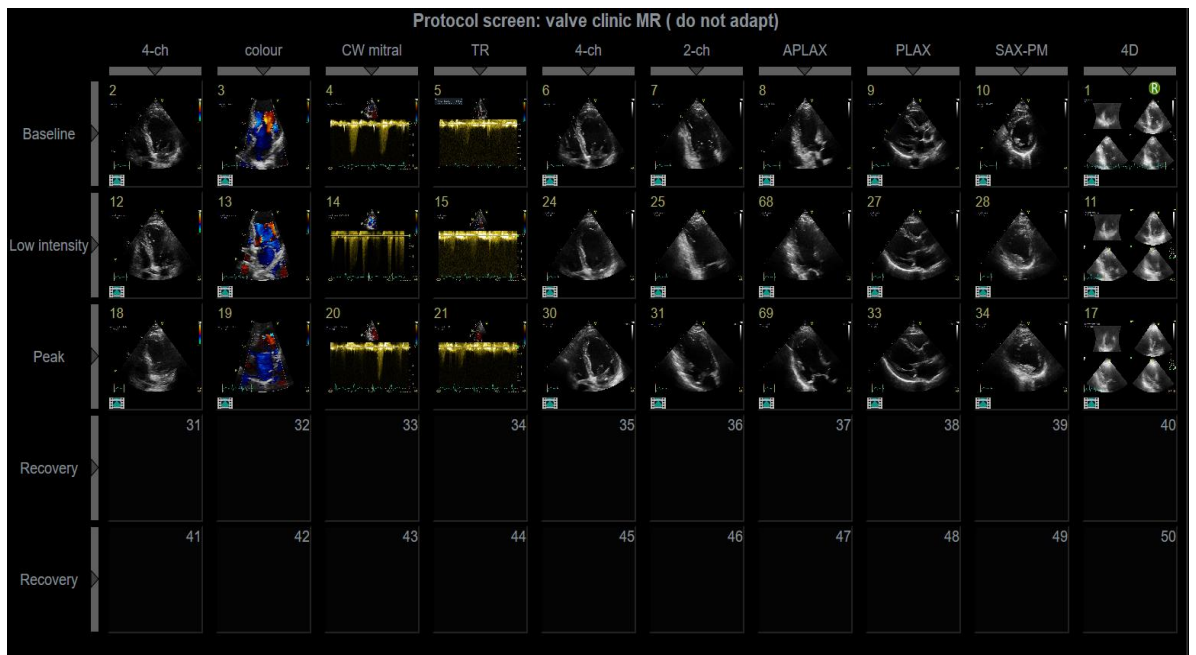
Stress exercise protocol with echocardiographic images were obtained at baseline, low-intensity exercise, and peak exercise levels. (Data from patient seen clinically at St. Bartholomew Hospital)
